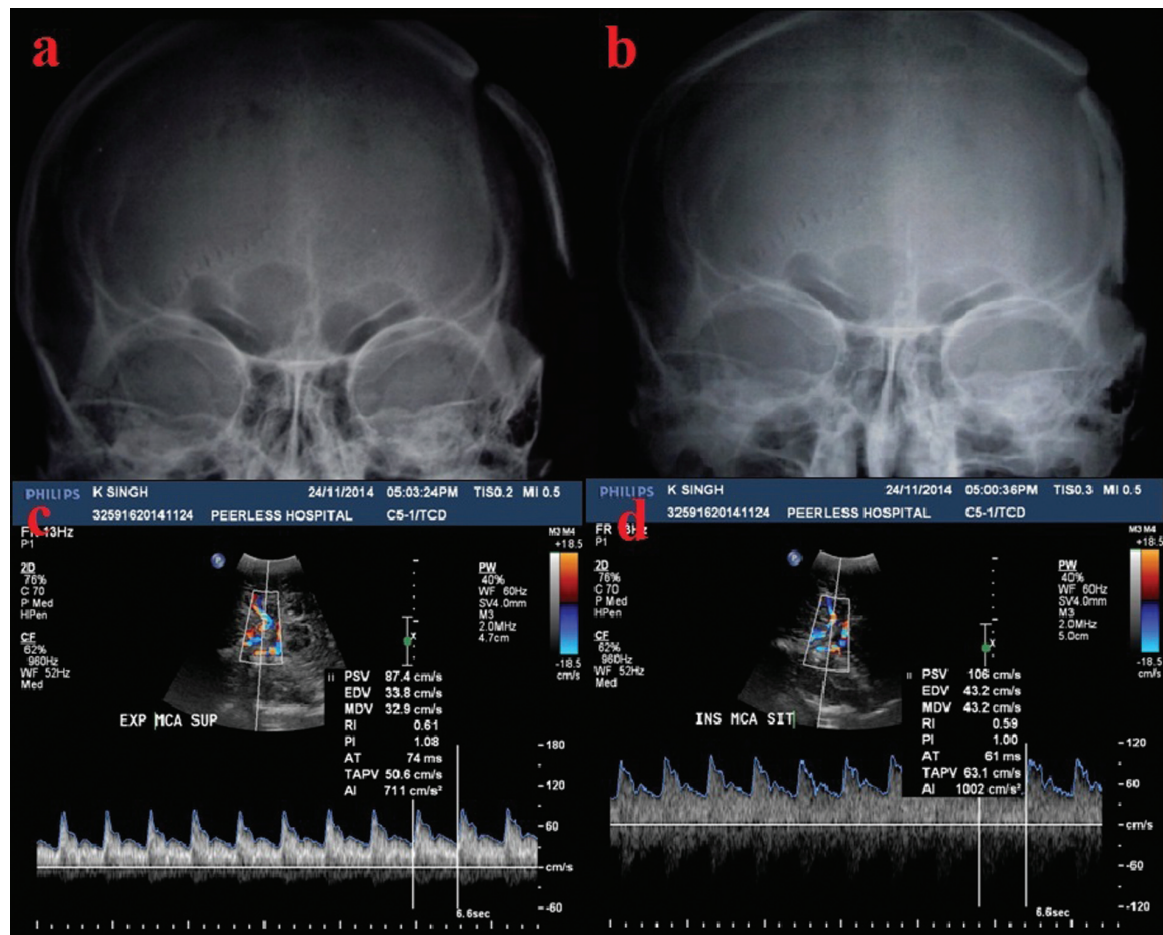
Anteroposterior plain skiagrams of a post CP mobile flap in supine position with full expiration (A) and sitting position with full inspiration (B) showing outward and inward mobility respectively. Transcranial doppler (C, D) showing increase in peak systolic velocity in the middle cerebral artery when the flap drifts inwards compared with that in supine position.
